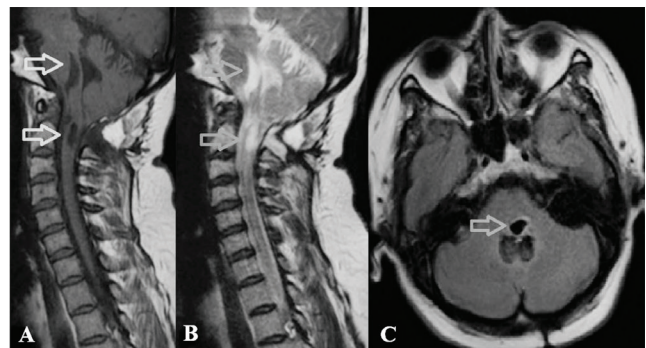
Magnetic resonance imaging (MRI) of the brainstem and spinal cord. T1-weighted (A) and T2-weighted (B) sagittal MRI of the brainstem and spinal cord revealing tonsillar herniation and hypointense (arrows) and hyperintense (arrows) cystic cavity corresponding to syringomyelia, respectively. T1-weighted axial MRI of the brainstem (C) showing the hypointense (arrow) cystic cavity corresponding to syringomyelia in the caudal tegmental region of the pons
